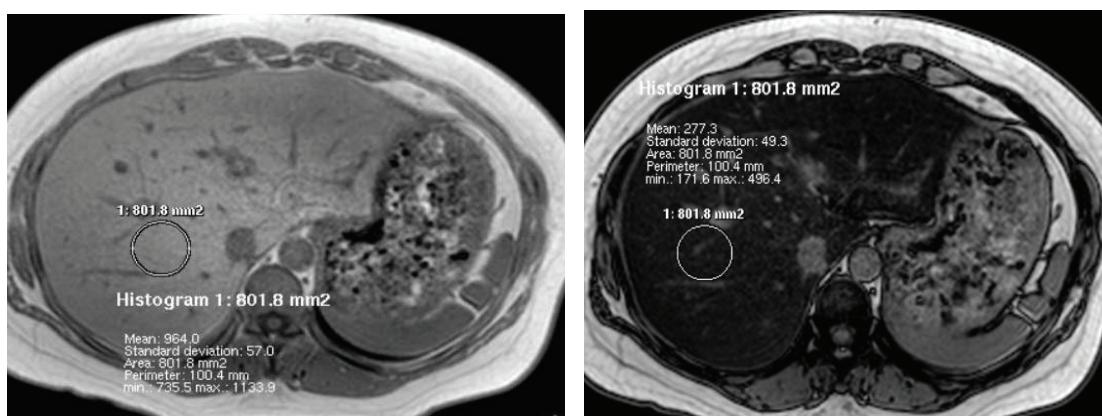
Chemical shift MRI for fat quantification in fatty liver
